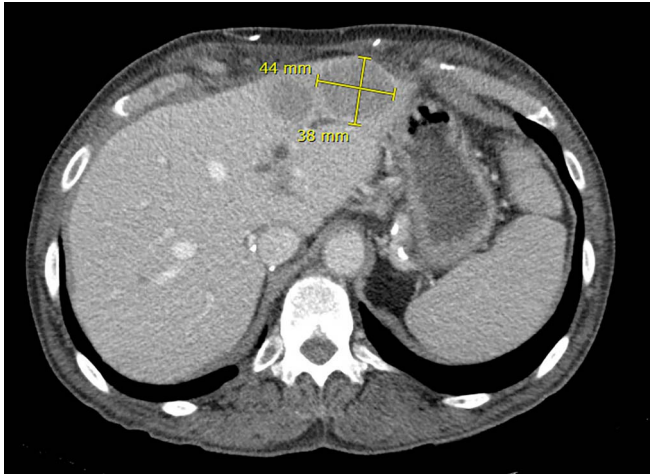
A computed tomography (CT) scan of the liver with intravenous (IV) contrast demonstrating multiple indeterminate liver masses, the largest measuring 4.4×3.8 cm. The masses were heterogeneously hypoenhancing relative to the background liver parenchyma with peripheral enhancement on arterial phase imaging and increasing enhancement on delayed phase imaging. Pictured is a representative slice during the arterial phase.
